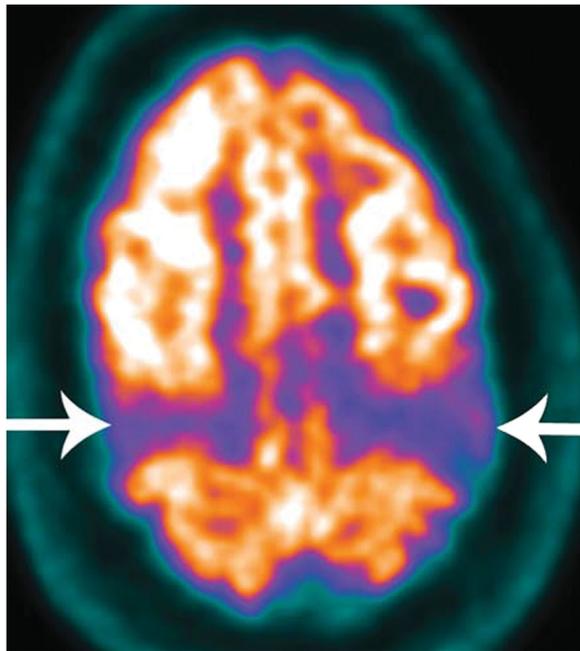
The stripe sign: selective vulnerability of motor neurons within the primary motor cortex (white arrows) demonstrated by severe hypometabolism on axial FDG-PET at a time when brain MRI had normal results. Adapted with permission from Cosgrove et al. (90).
